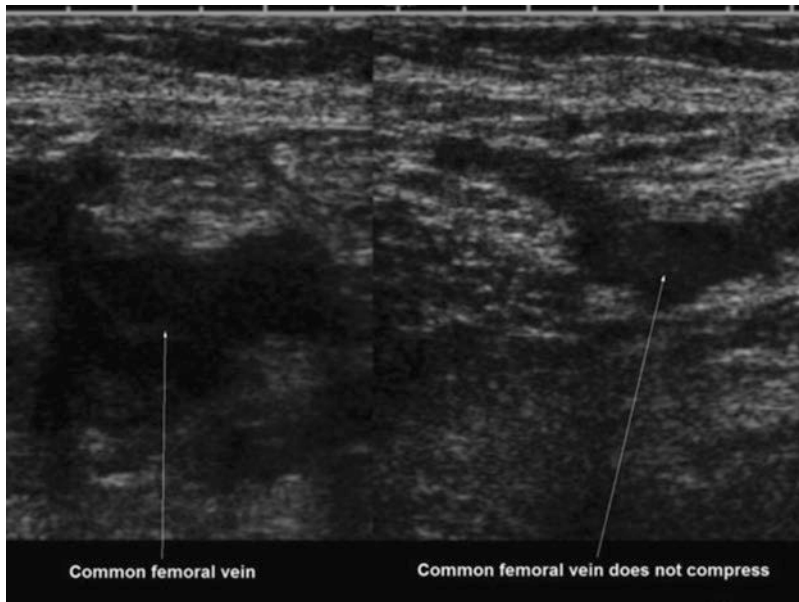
The transverse ultrasound scan shows the left common femoral vein before (*left*) and after compression (*right*) in the 39-year-old woman depicted in Fig. 13.18. Incomplete compression (*right*) indicates the presence of a thrombosis within the lumen [Reprinted from Swanson
